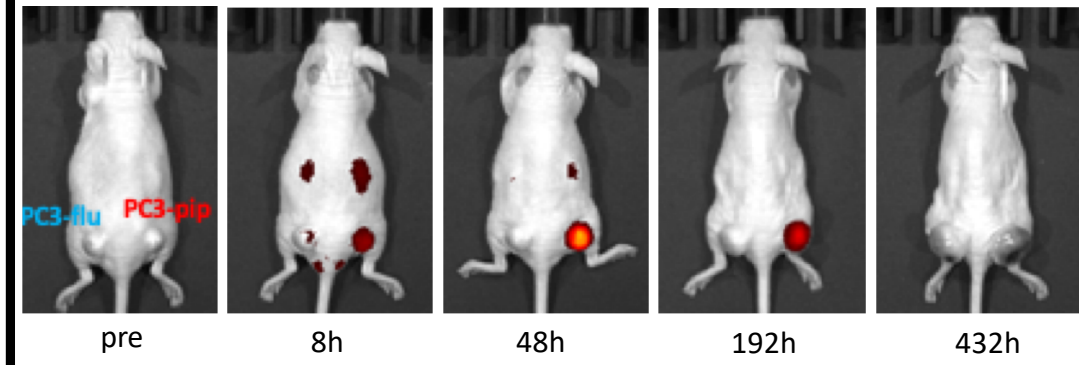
Selective accumulation of PSMA-1-ICG in PSMA positive PC3pip tumors.
